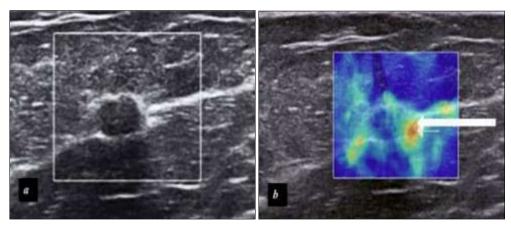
(a) A case of biopsy proven invasive carcinoma. B mode ultrasound characteristics wrongly interpreted the lesion as benign. (b) SWE showed suspicious peri-tumoral stiffness which helped to raise the suspicion of malignancy and opt for a biopsy
